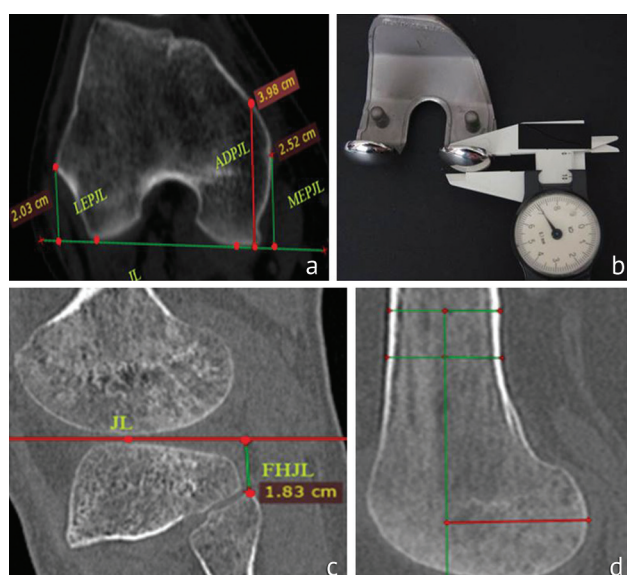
CT scan of the knee joint, presurgical planning: (a) measurement of the distance from the condyles of the femur to the flexion line using an axial image; (b) measurement of the thickness of the posterior flange of the implant; (c) measurement of the level of the knee space relative to the fibula using a sagittal view; (d) measurement of the level of posterior resection of the femur
